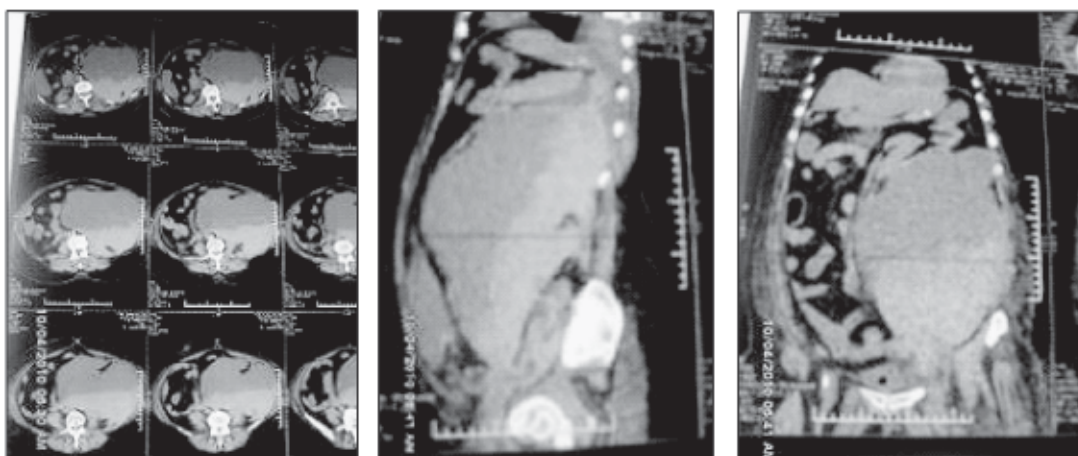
CT Scan of Abdomen showed huge well defined mixed density retroperitoneal mass extending from upper quadrant to the left side of the pelvis.
